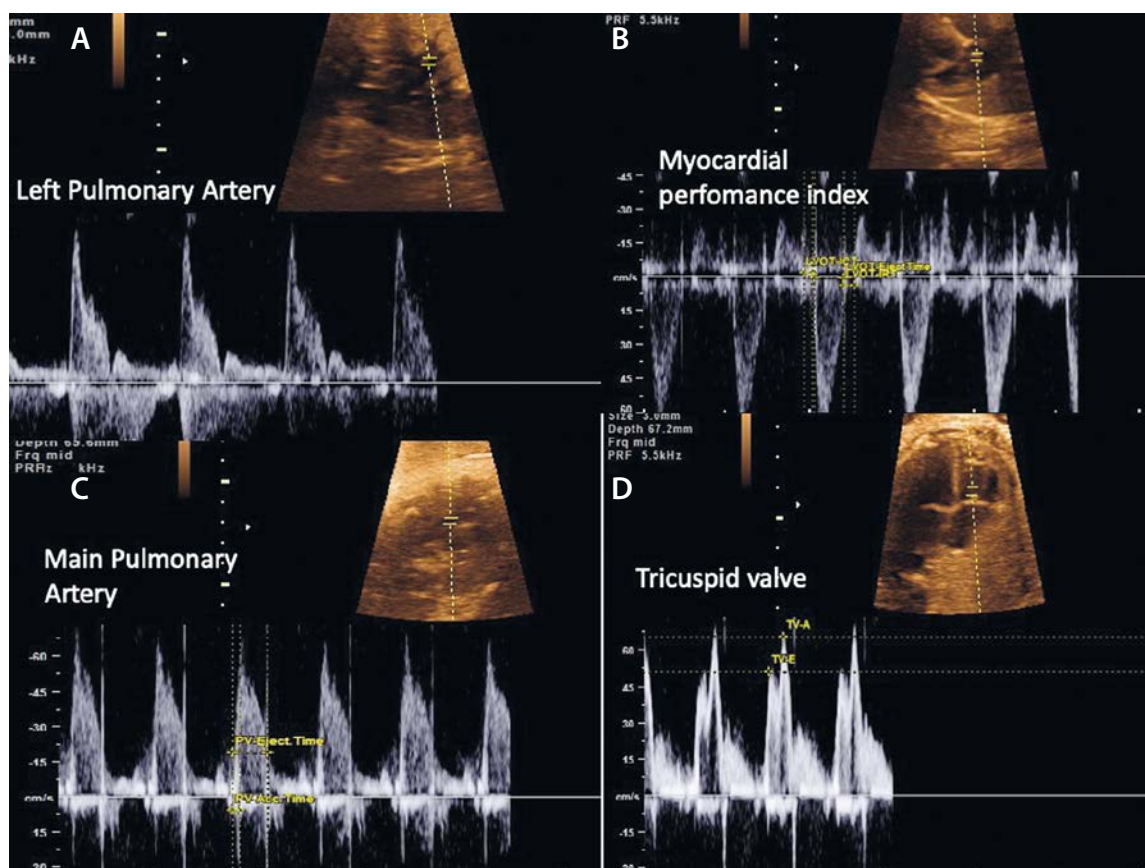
Cardiac Doppler (A) left pulmonary artery branch, (B) myocardial performance index with ICT, IRT, and ET, (C) main pulmonary artery with AT and ET, and (D) tricuspid valve with E-wave and A-wave
